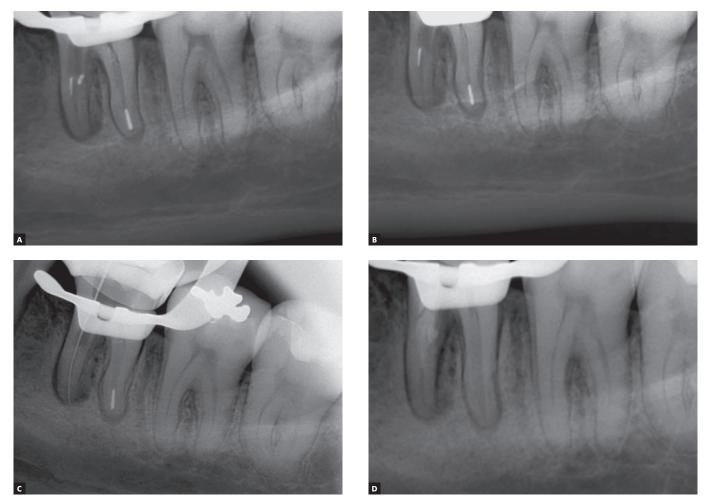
Transoperative: A) Periapical radiograph of lower left first molar, in which it is possible to visualize the secondary fragment. B) Periapical radiograph of lower left first molar after removal of the secondary fragment. C) Periapical radiograph of lower left first molar showing that the canal path was unblocked. D) Periapical radiograph of lower left first molar after insertion of dense calcium hydroxide paste in the mesiobuccal canal.
